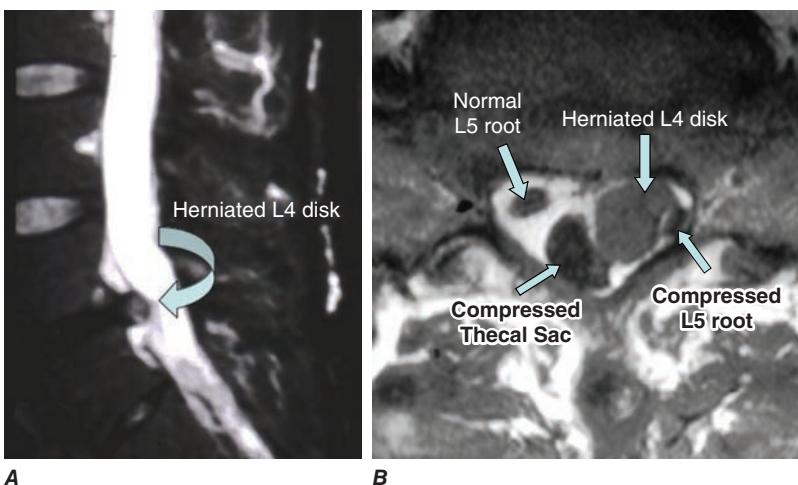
Disk herniation. A. Sagittal T2-weighted image on the left side of the spinal canal reveals disk herniation at the L4-L5 level. B. Axial T1-weighted image shows paracentral disk herniation with displacement of the thecal sac medially and the left L5 nerve root posteriorly in the left lateral recess.
